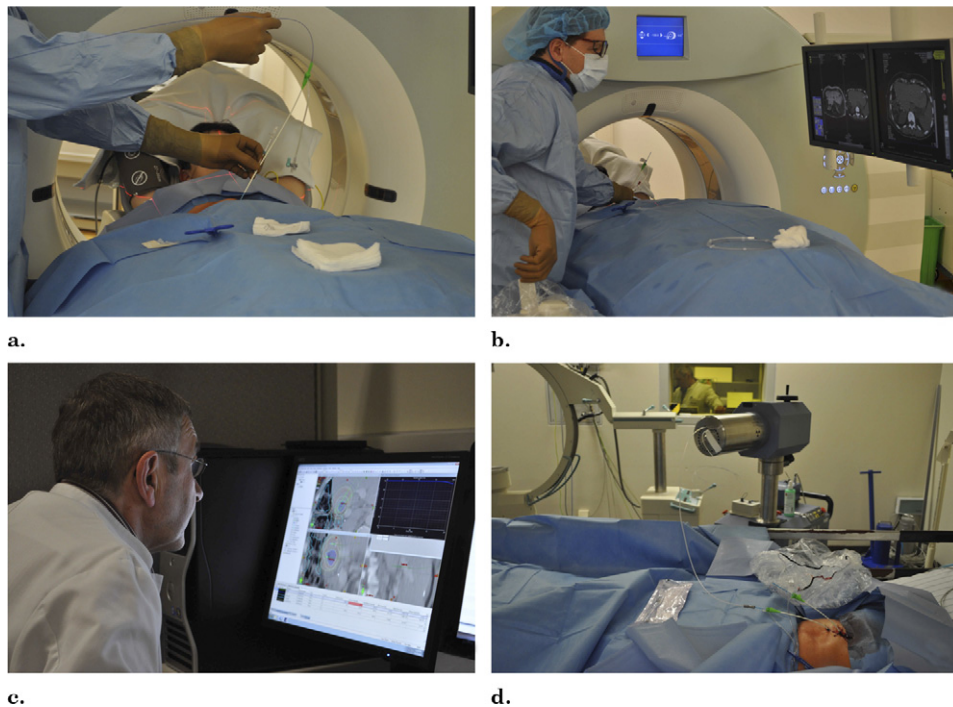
(a, b) Catheter implantation under CT fluoroscopy. (c) Computer-based three-dimensional treatment planning on a dedicated workstation. (d) High-dose-rate irradiation in afterloading technique using an iridium-192 radiation source.
